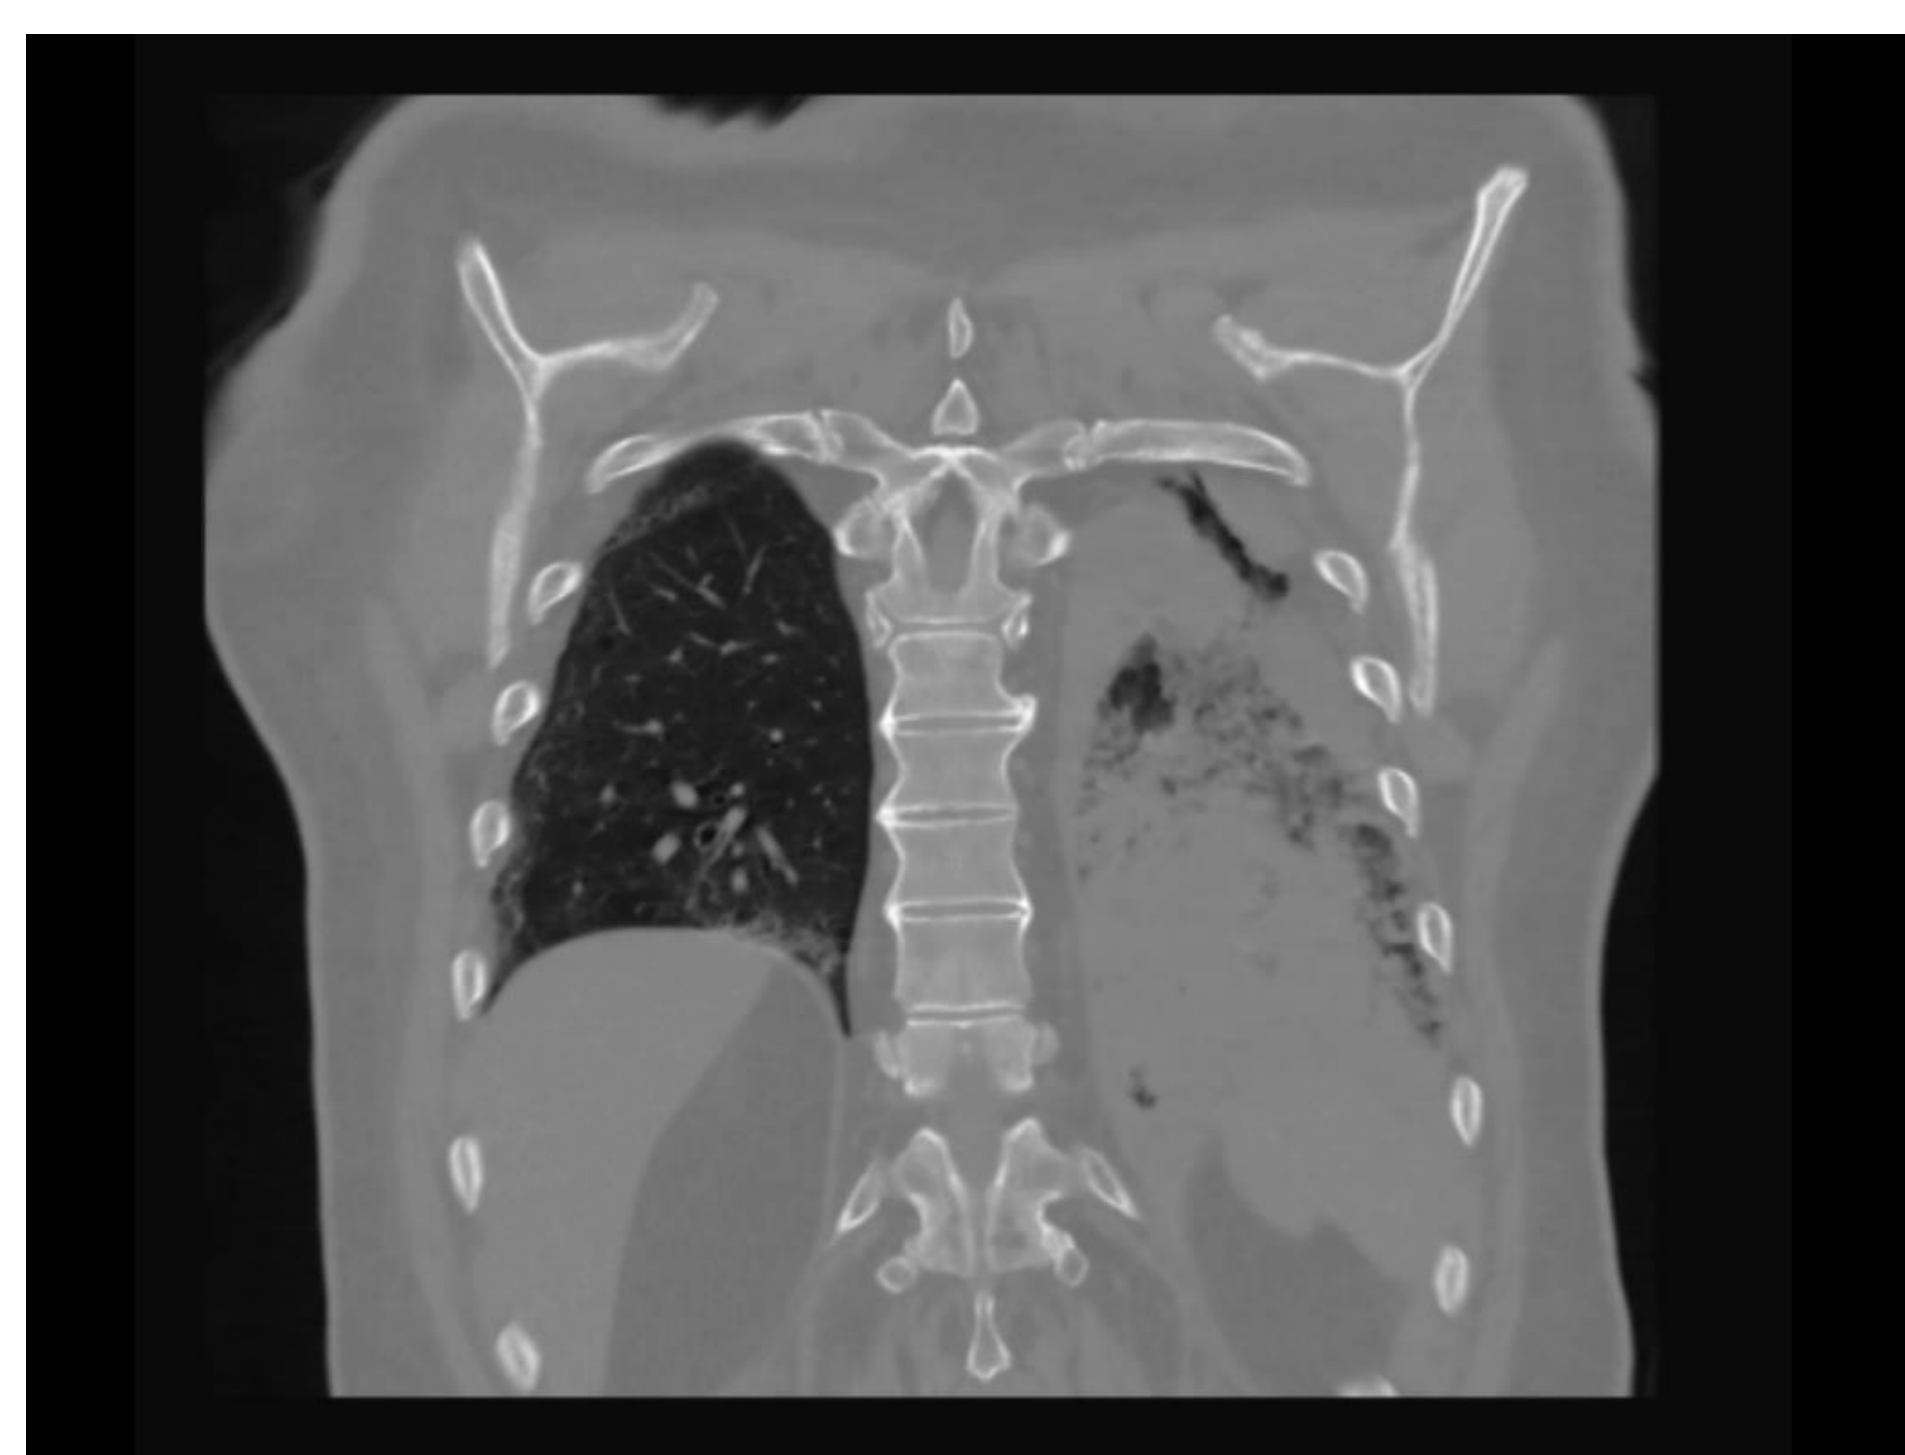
CT Chest without contrast showing multifocal aspiration pneumonia.
